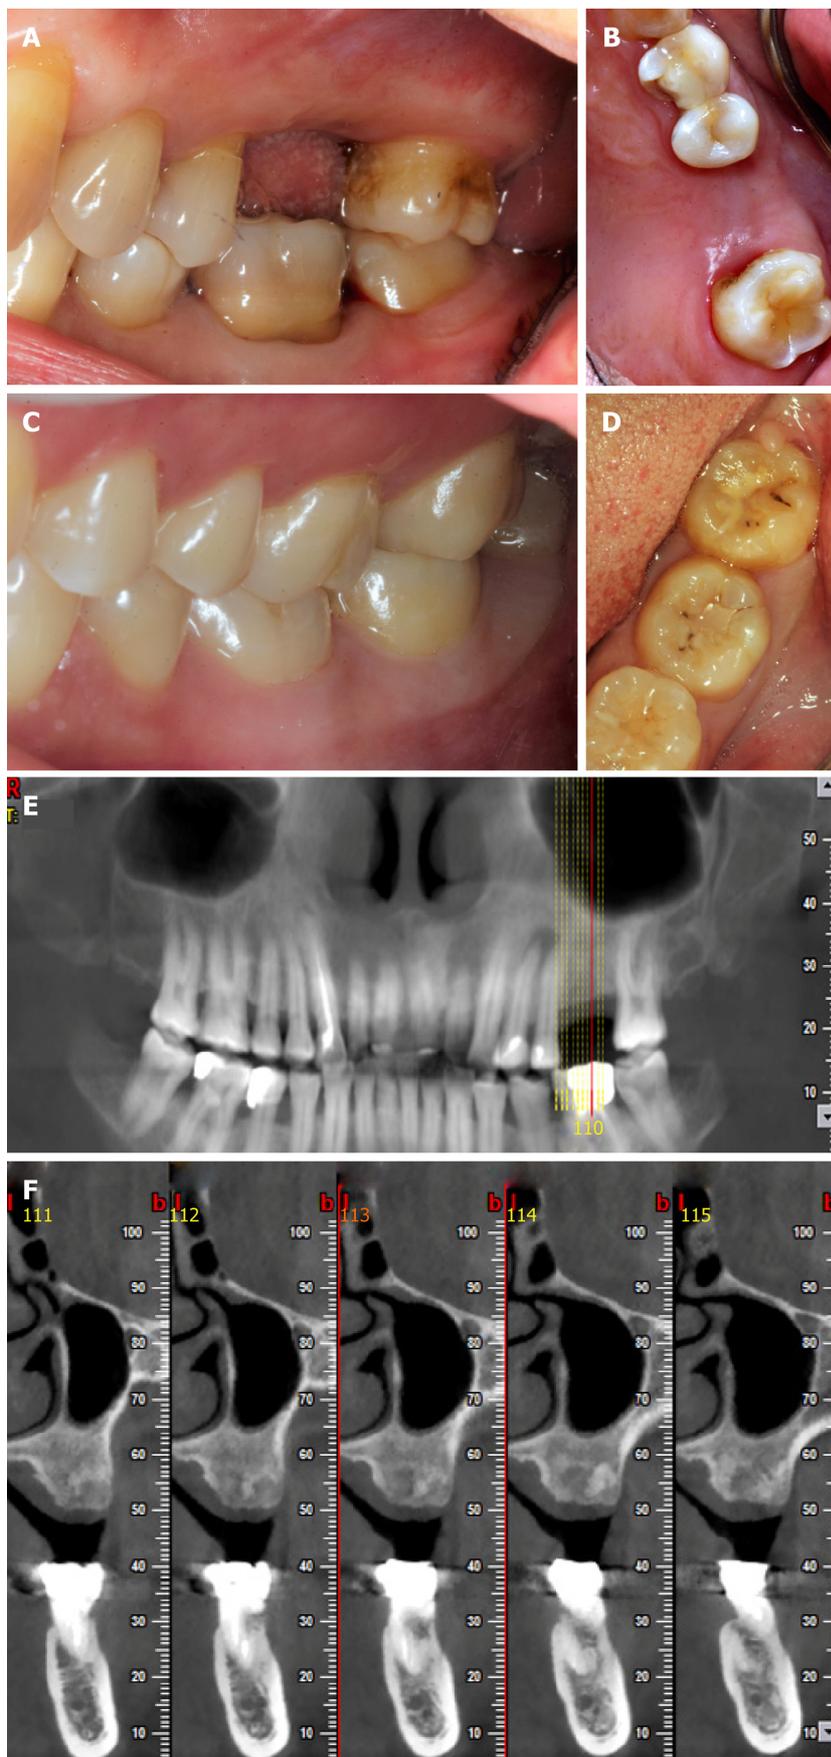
Preoperative photos and computed tomography scan of the donor and the recipient. A and B: Occlusal photos showing the recipient's missing #26; C and D: Occlusal photos showing the donor's #48; E: The recipient's orthopantomogram taken before the surgery; F: Computed tomography image showing the cross section of the bone at #26.
